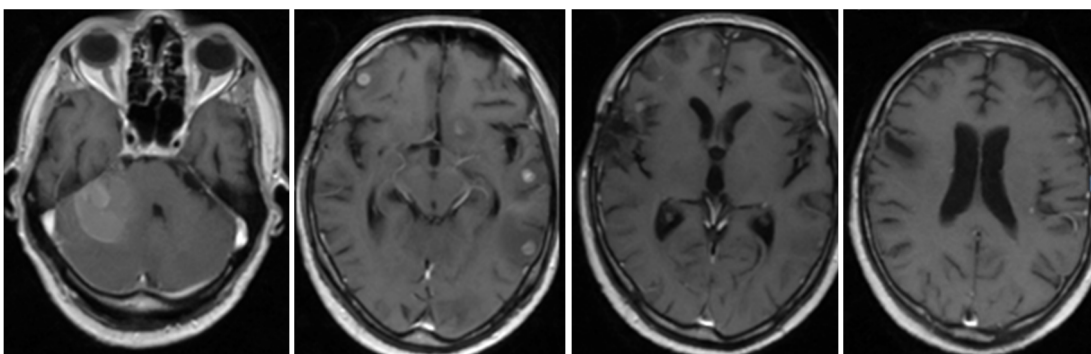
Case 3 - MRI T1 enhanced: posterior fossa lesion with multiple other supratentorial lesions
